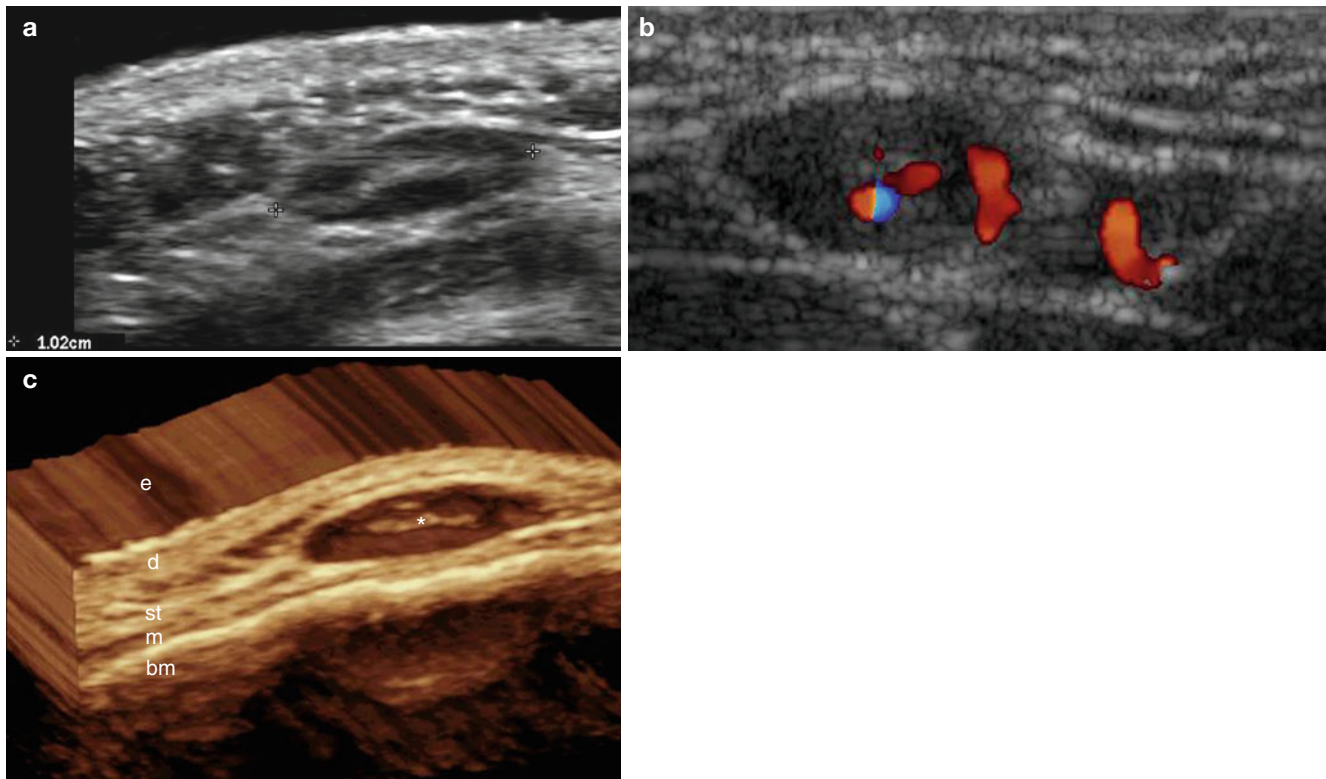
(a–c) Lymph node anatomy. (a) Ultrasound (gray scale) shows 1.02 cm oval-shaped structure (between markers) with continuous hypoechoic cortex and well-defined hyperechoic center. (b) Color
